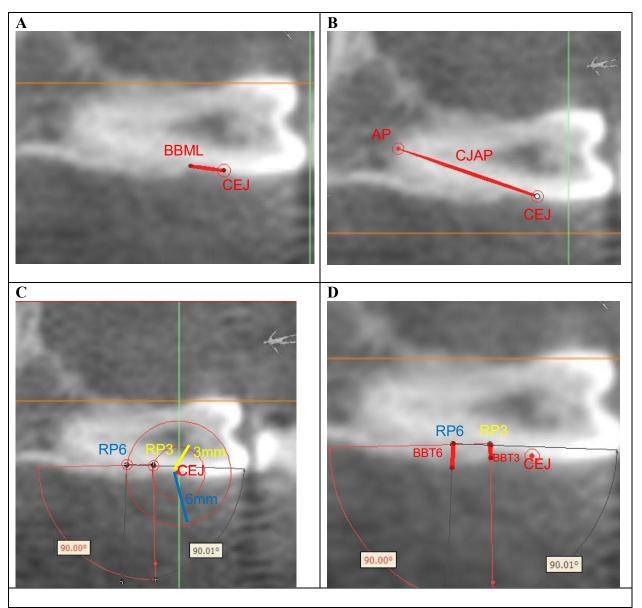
CBCT Analysis of buccal bone variable.
